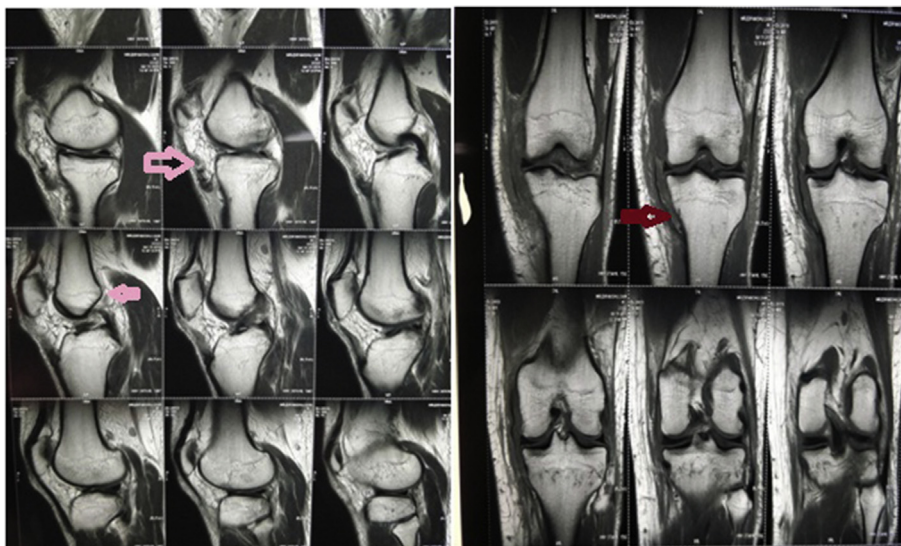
MRI (Sagittal & Coronal) images of patient 1, Arrows denote Patellar Tendon tear, buckling of Posterior cruciate ligament suggestive of ACL injury & Medial collateral ligament avulsion from femur side.
